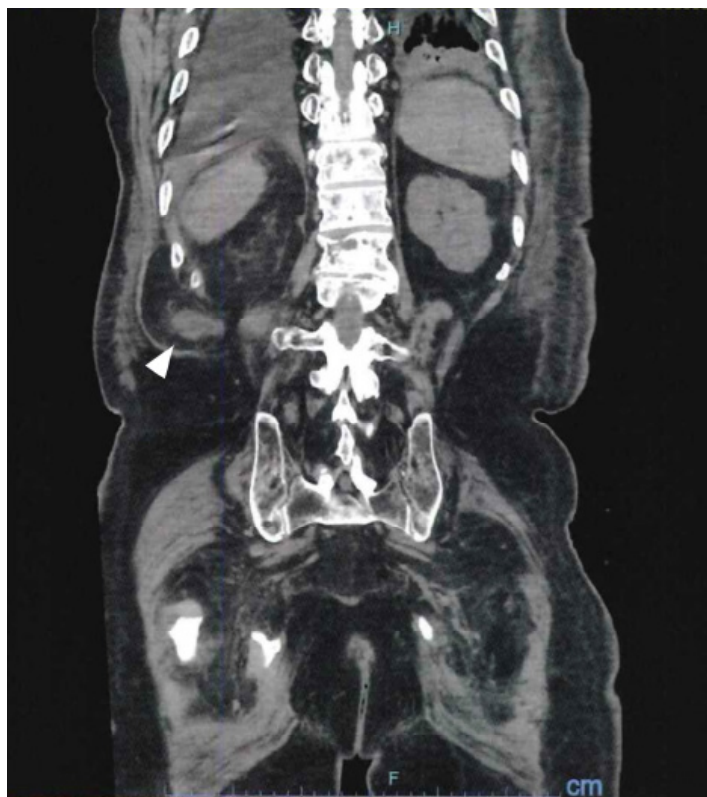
Computed tomography (coronal view) showing the herniated ureter through the Petit triangle (arrow).
